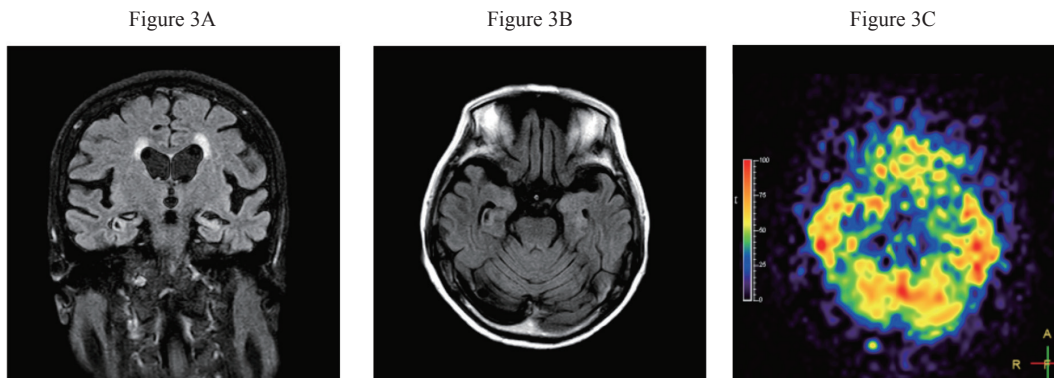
The findings of MRI on 33rd day after admission.
